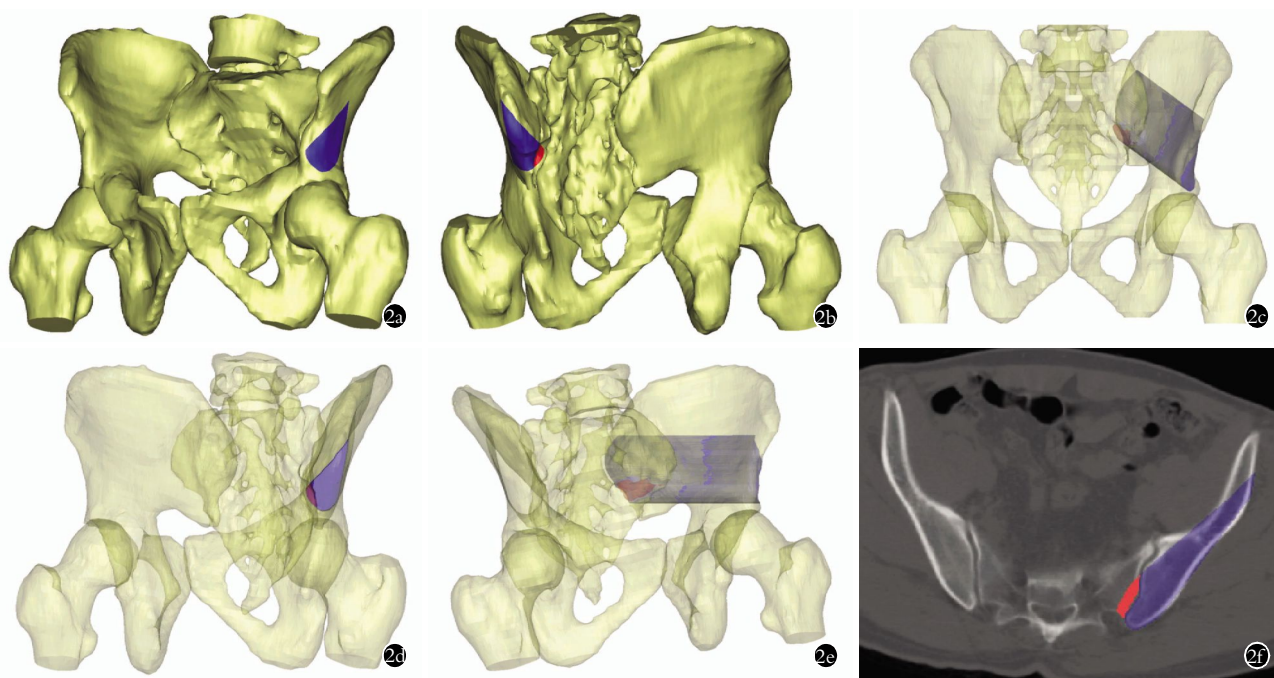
骨盆 Teepee 像主体结构在骨盆内的方位走行及其影像解剖构成(45 岁男性) 2a. 骨盆 Teepee 像(前后)显示主体(蓝色区域)的前方起点 2b. 骨盆 Teepee 像(后前)显示主体(蓝色及红色区域)的后方止点 2c. 骨盆正位像显示主体(蓝色及红色区域)的走行方向 2d. 骨盆 Teepee 像显示主体的解剖构成 2e. 髂骨斜位像显示主体(蓝色及红色区域)的头端及尾端界限 2f. 骨盆轴向 CT 平扫像显示主体(蓝色及红色区域)的解剖构成
